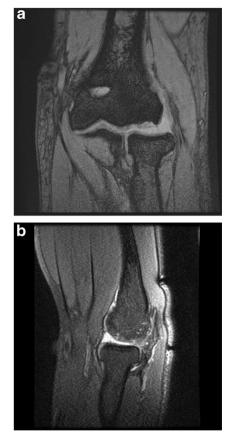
a, b Post-operative coronal and sagittal T2 MRI—demonstrating restoration of congruent articular surface
